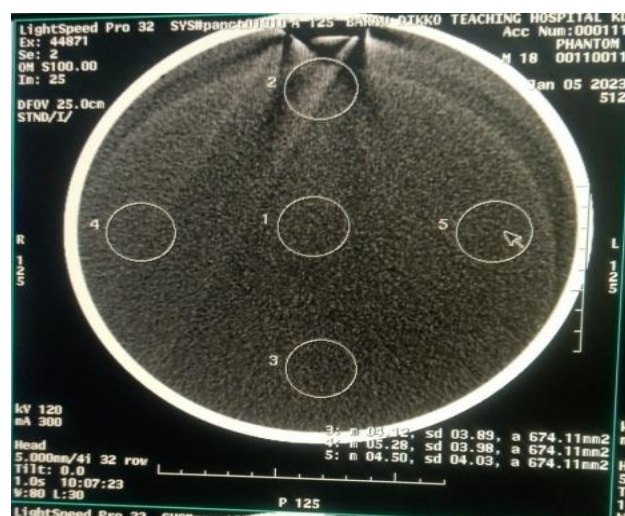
Scanner I CT QC image for: 1 (Mean values for water and image noise), 2-5 (field uniformity)
